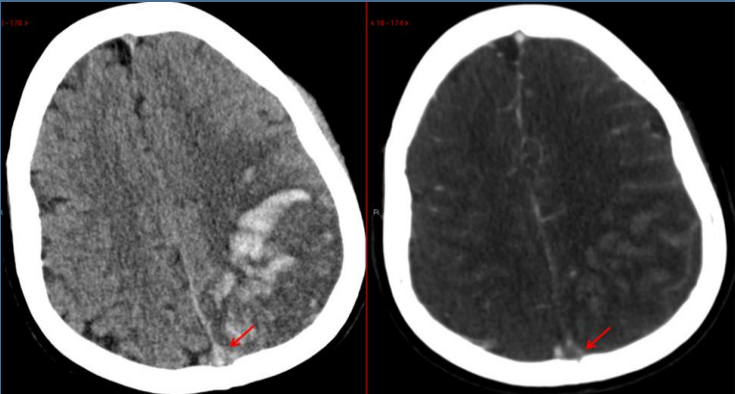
Hyperdense superior sagittal sinus on native CT (left) and filling defect on contrast enhanced CT (right) indicating sinus thrombosis.
